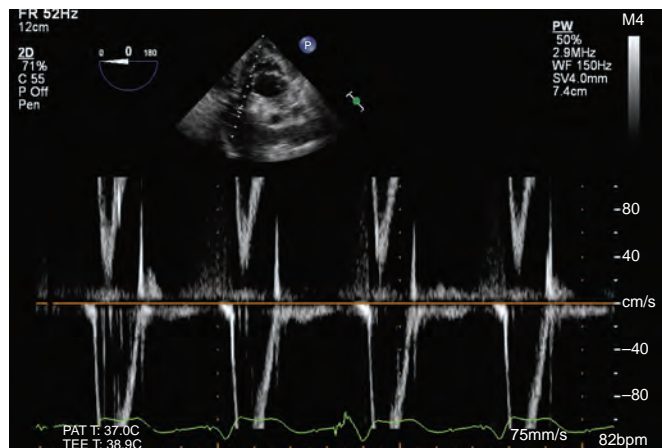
Example of aliasing (deep transgastric view). Pulsed-wave Doppler through the aortic valve is demonstrated. Because the blood-flow velocity through the aortic valve is very high, it appears to wrap around the velocity scale when pulsed-wave Doppler is used.
